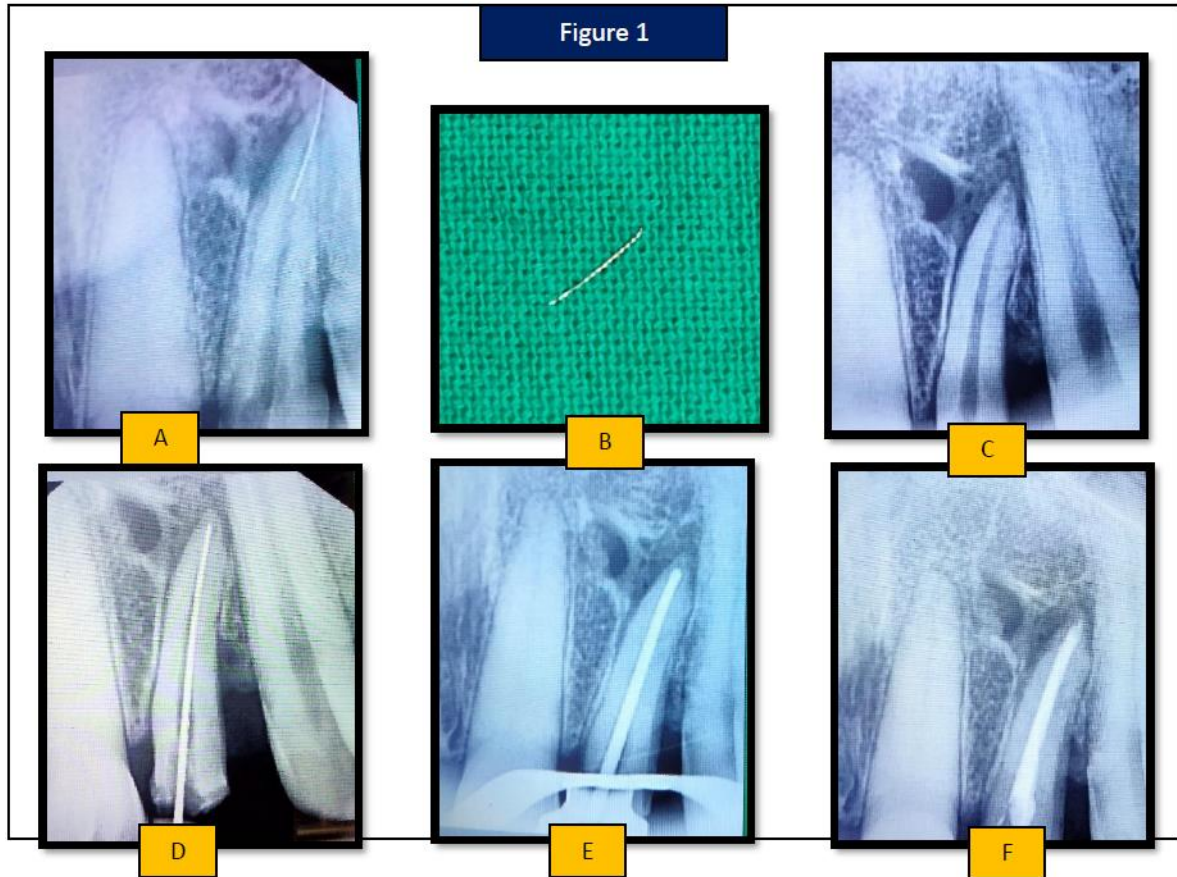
A. Radiographic Picture of Fractured File B. File After Retrieval C. Radiograph After File Retrieval. Working Length E. Master Conef. Obturation
